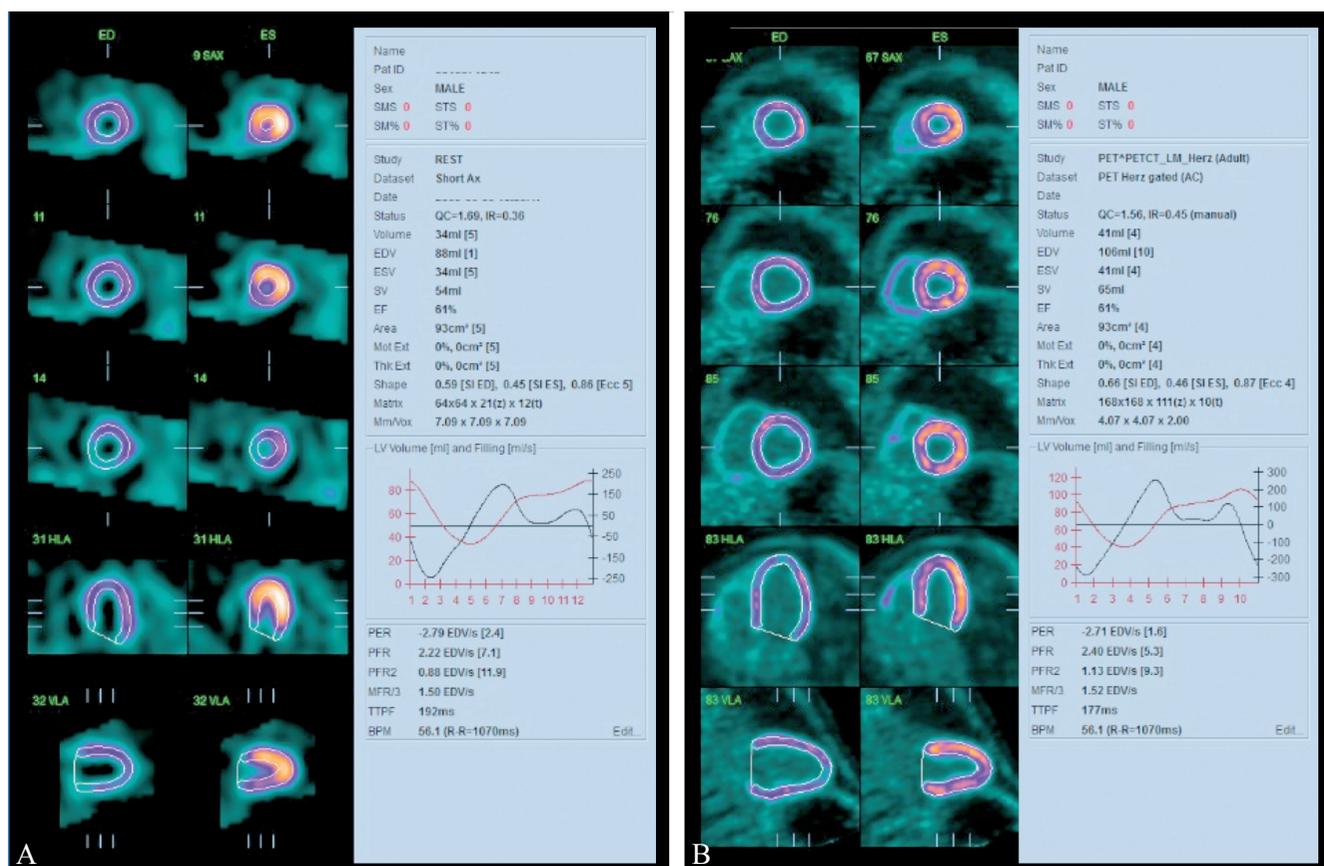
A) Representative images of gated MPS; and B) gated FDG PET. In each panel the left column shows end systole, the middle column end diastole and the right column the left ventricular functional parameters. Note that PET detects a proportionally larger EDV and ESV as compared to SPECT, probably due to superior image resolution and reduced partial volume effects. LVEF is equal.
